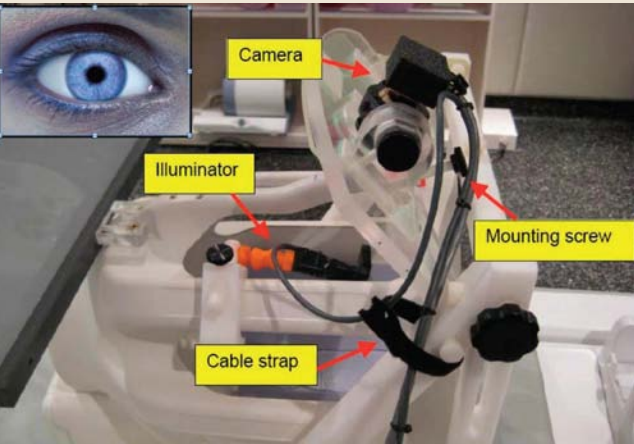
A new eye tracker was designed and constructed (www.magconcept.com/MRI) for use with the 8-channel receive-only phased array head coil during functional brain imaging at the 3T2 MRI. Knowing where the eye gaze is focused or what the pupil diameter is reveals behavior important to understanding brain results for many studies.
